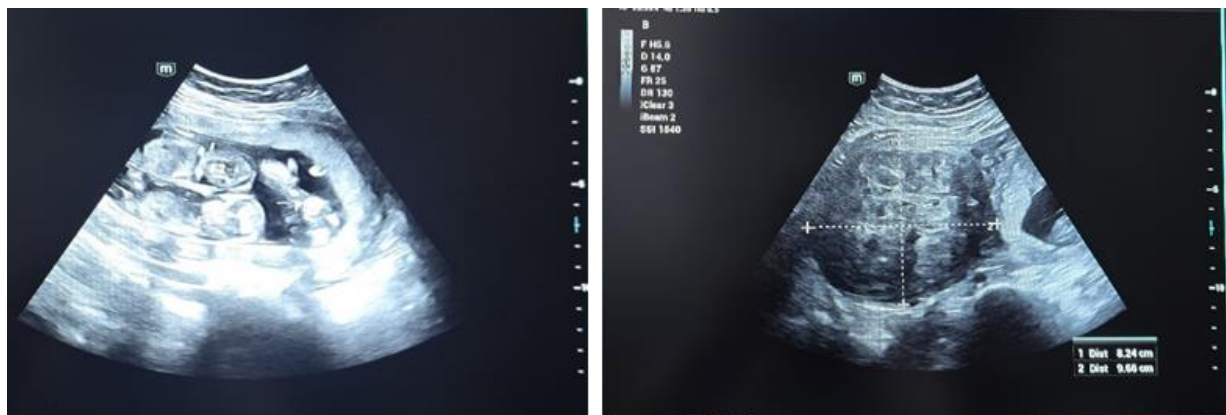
Ultrasonographic findings of the patient
